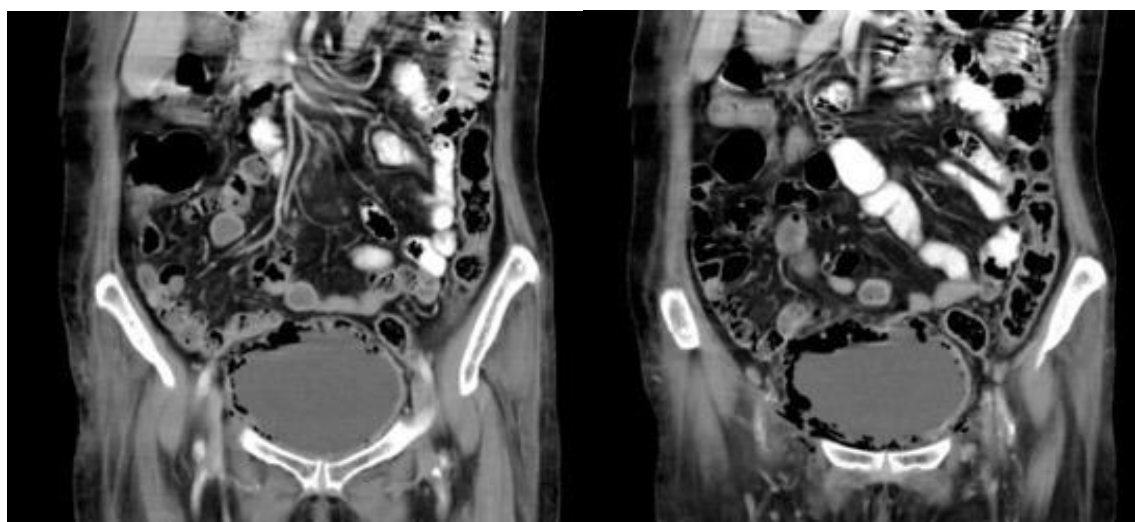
Computed tomography (coronal view) revealed multiple air foci in the bladder with thickening of the bladder.
